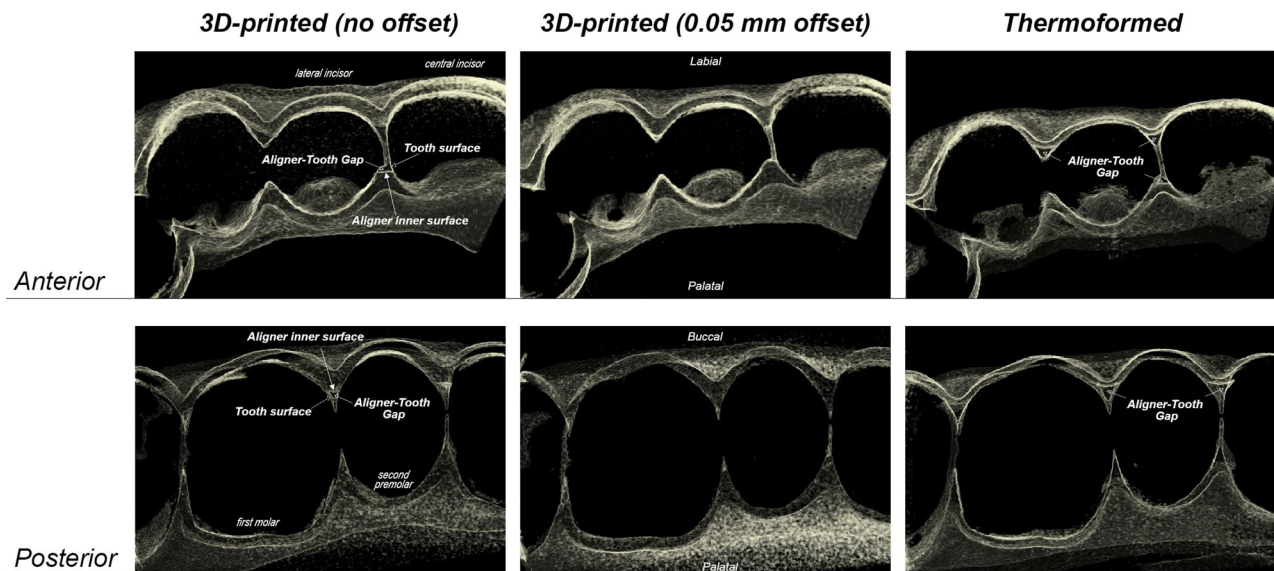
Inverted three-dimensional microcomputed tomographic occlusal views of the cervical half region, showing aligner–tooth gaps at the embrasures
